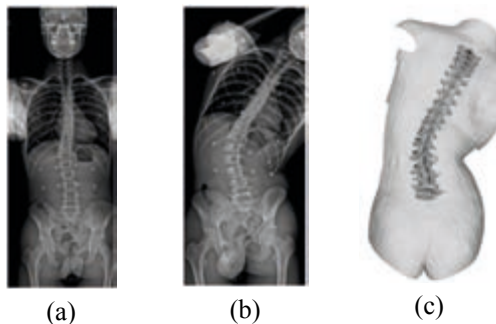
Coronal views in bi-planar radiographs of the patient in standing (a) and bending (b). The resulting 3D avatar of the patient in bending (c).
